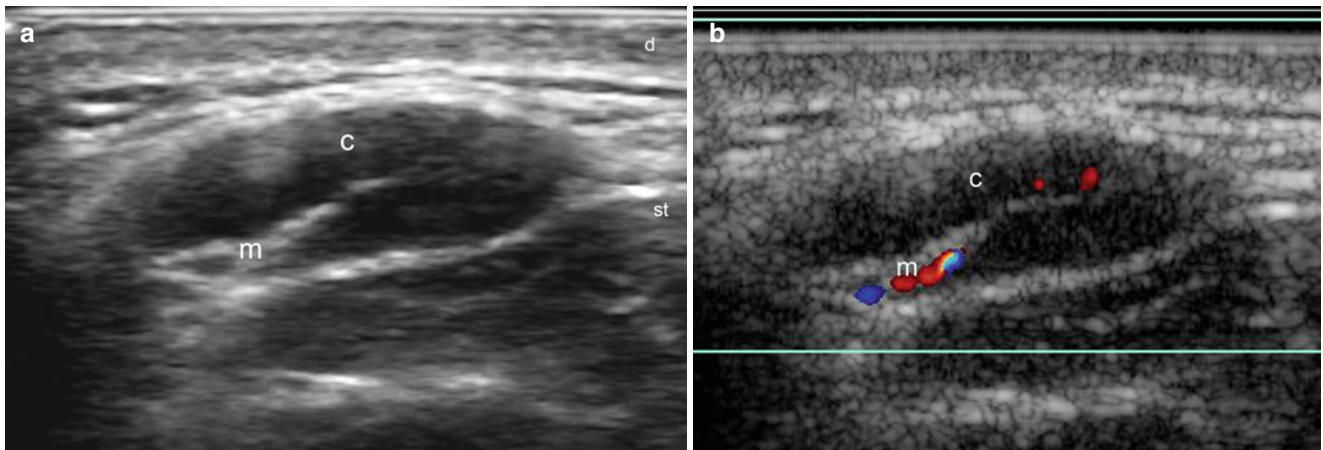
(a, b) Inflammatory lymph node. (a) Grey scale ultrasound image (transverse view) shows a well-defined, oval-shaped subcutaneous structure that presents a thick hypoechoic rim (cortex) and band-like hyperechoic center (medulla). (b) Color Doppler ultrasound image
